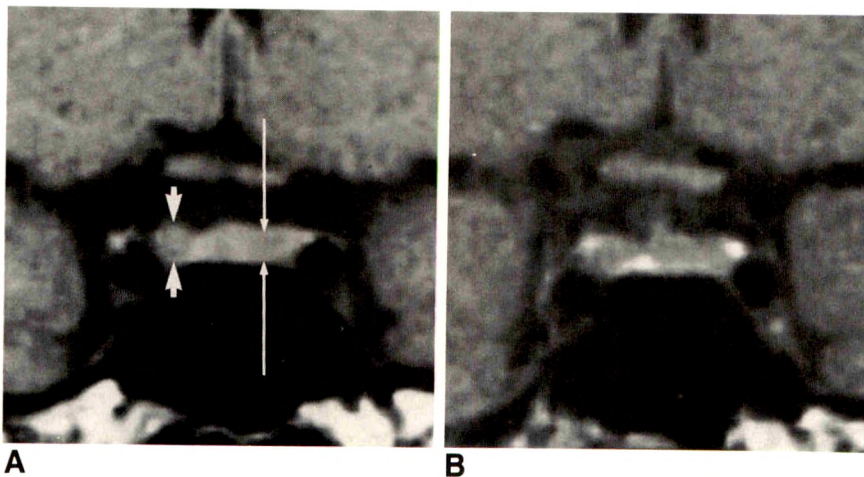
A and B, 38-year-old woman with Cushing disease. T1-weighted coronal images, 600/20. Well-defined prospectively identified 4-mm focus of low signal in right lateral wing, adjacent to medial dural reflection of cavernous sinus (short arrows). Less well defined 5-mm region of low signal on left (long arrows) not identified prospectively. Stalk is midline. At surgery, right side was normal, and 6-mm ACTH-secreting adenoma was found in left lateral wing, corresponding to low intensity identified (long arrows). (Right half = false positive; left half = false negative.)
